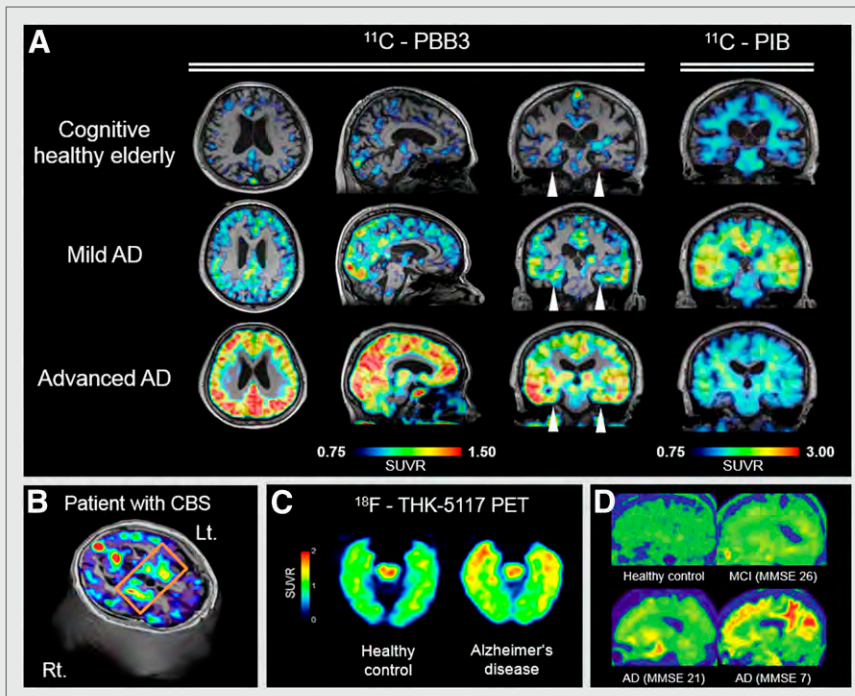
Tau PET scan images in humans. (A) Coregistered MR imaging and ^{11}C -PBB3 parametric standardized uptake value ratio (SUVR) images compared with ^{11}C -Pittsburgh compound B. No significant radiotracer retention is seen in cognitively healthy elderly subject. Note different uptake pattern in hippocampus between ^{11}C -PBB3 and ^{11}C -Pittsburgh compound B across subjects (arrowheads), and spread of ^{11}C -PBB3 accumulation to cortical areas in advanced AD patient, who shows some cortical uptake in ^{11}C -Pittsburgh compound B scan. (B) ^{11}C -PBB3 PET axial slice over 3-dimensional MR imaging of corticobasal syndrome patient with left-sided symptomatic predominance, showing ^{11}C -PBB3 accumulation in right basal ganglia (Courtesy of Drs. Hitoshi Shimada and Makoto Higuchi). (C) ^{18}F -THK-5117 PET SUVR images (50–60 min after injection). Higher tracer uptake in anterior pole and mesial aspect of temporal lobes in AD patient (87 y old, MMSE 25) compared with healthy control (80 y old, MMSE 28). Activity in midbrain may represent nonspecific binding (Courtesy of Dr. Nobuyuki Okamura). (D) ^{18}F -T807 sagittal images (80–100 min after injection). No significant radiotracer uptake is seen in healthy control (56 y old), whereas progressive radiotracer accumulation and spreading from mesial temporal to neocortex is seen in patients as MMSE scores decrease. (Reprinted with permission of (20).)
